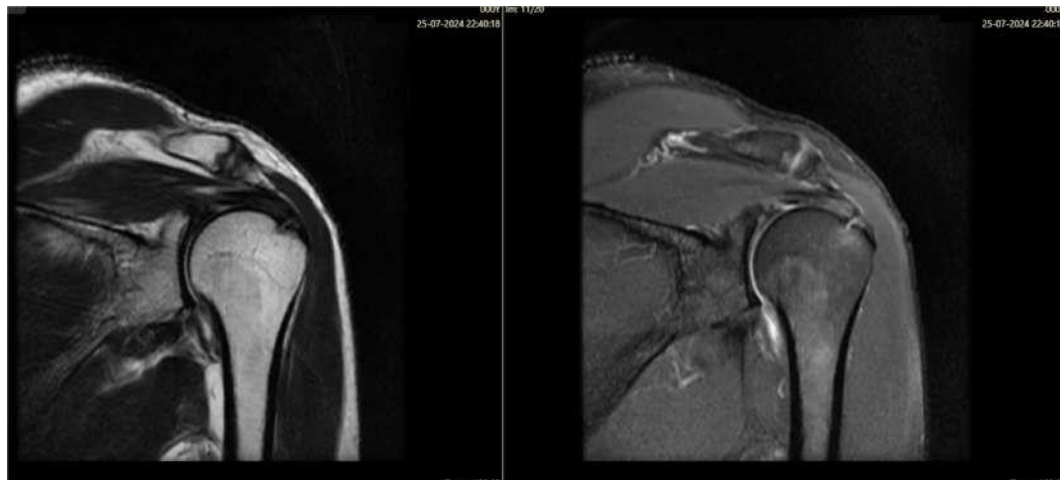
MRI images in coronal show a full-thickness tear of the supraspinatus
